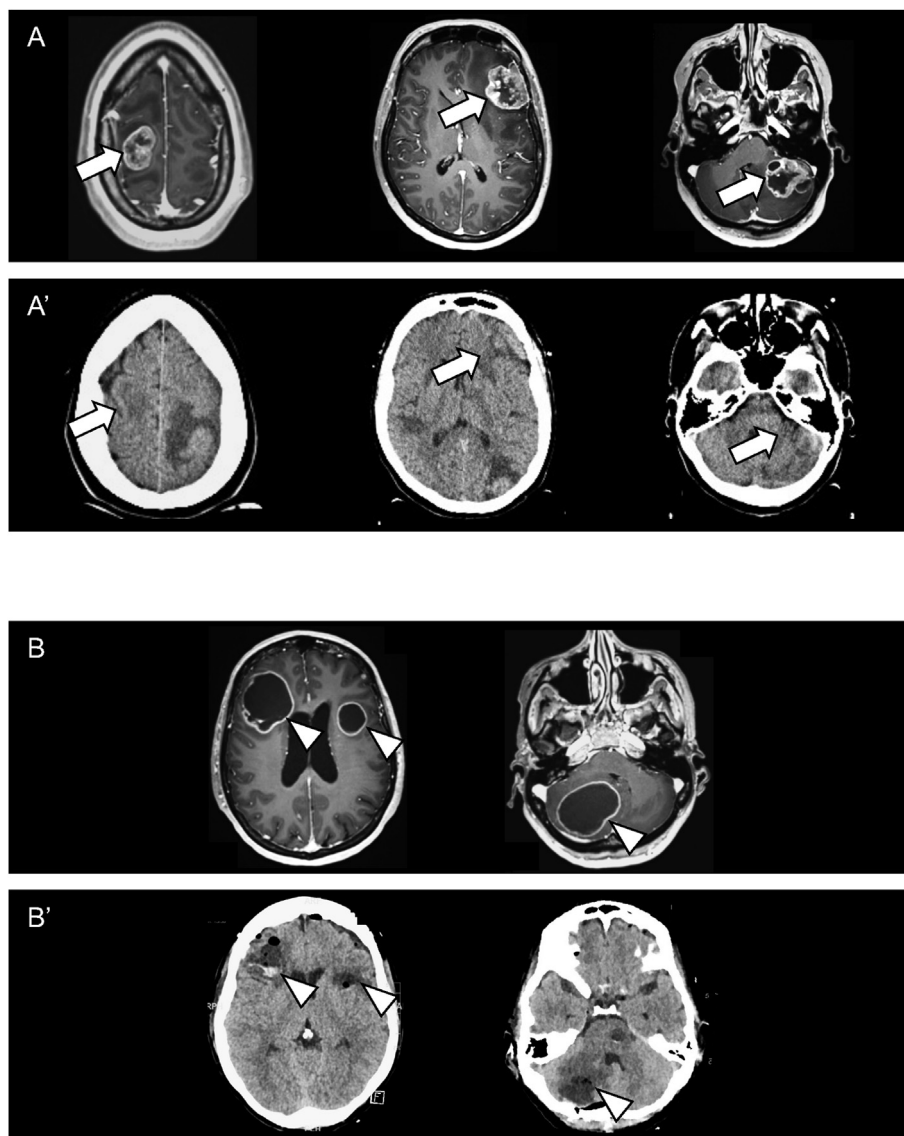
Surgical resection of multiple metastases enabling further therapy. A: Gd-enhanced MRI of a 39-year-old female with known breast cancer developing a left-sided hemiparesis. The dilemma consisted of a large metastasis threatening hydrocephalus, a left frontal metastasis with signs of dysphasia, and the symptomatic right sided lesion in addition to 6 more lesions (arrows). A': As there was a surgical indication for each lesion, all lesions were removed in one session without any sequelae as seen on the CT immediately post-OP before awakening the patient after the successive craniotomies. WBRT was started four weeks after surgery. B: Gd-enhanced MRI of a 50-year-old non-smoker who presented with headache and nuchal pain thought to arise from the cervical spine. On MRI, three lesions (arrowheads) with initial signs of hydrocephalus were seen; and subsequently a suspicious lesion was found in the lung. B': Analogous CT on the way between surgery and post-OP ward showing uneventful removal in one session of all three lesions, each of which had a surgical indication. This enabled molecular analysis showing an Exon 19 EGFR mutation as well as a p53 mutation allowing targeted therapy in addition to WBRT, which in the presence of the lesions would have had to be abandoned with high probability due to exhausted brain compliance with mass effect and hydrocephalus.
